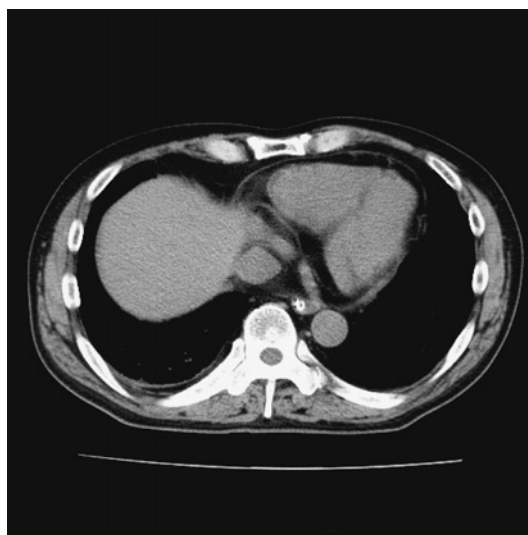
CT 3 days after the second operation
